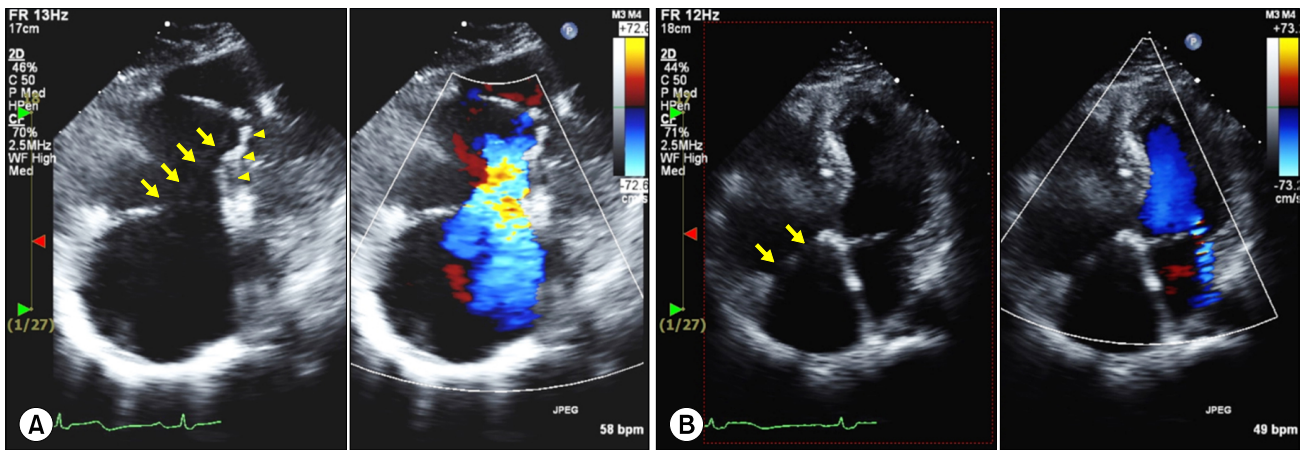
Echocardiogram of case 2. (A) A large mobile anterior leaflet (arrows) and the displaced septal leaflet (arrow heads). Color Doppler scanning reveals severe tricuspid regurgitation. (B) The newly constructed leaflet edges are present at the true tricuspid annulus level (arrows), without any tricuspid regurgitation.
